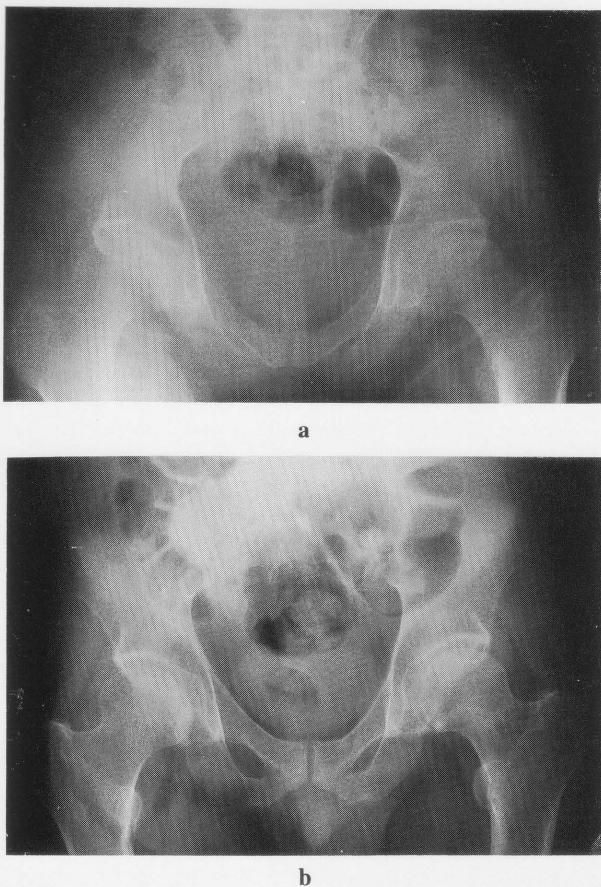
Radiographs of pelvis (a), before treatment, demonstrates generalized demineralization and pseudofractures in the neck of the left femur, both superior and inferior pubic rami. (b), after treatment, marked improvement is seen.
